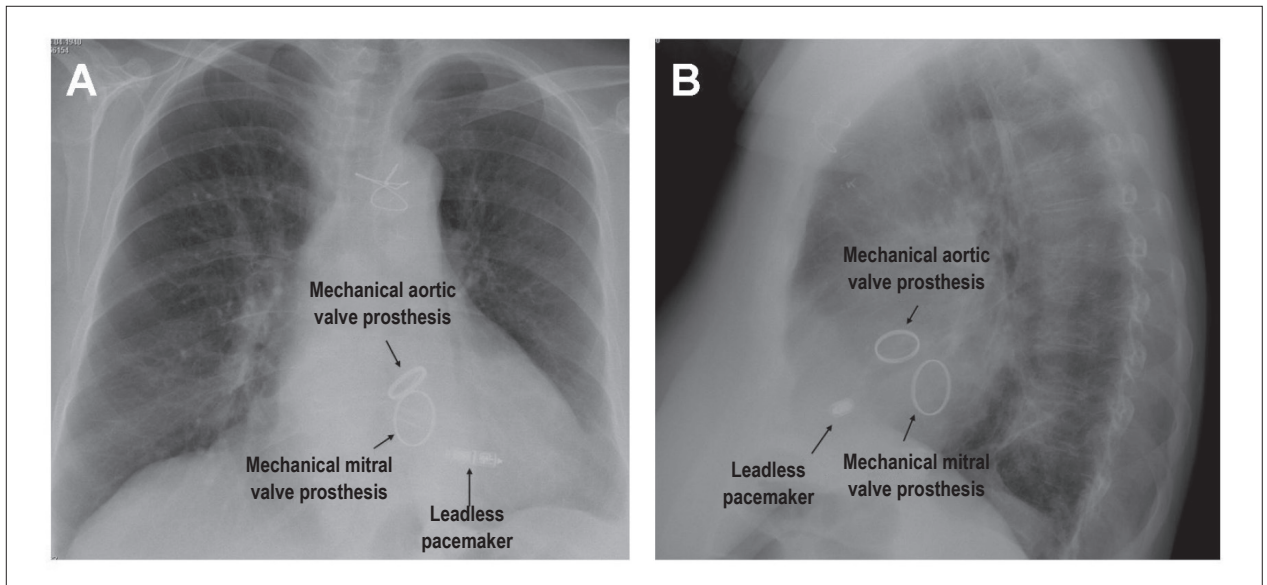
Chest X-Ray of the patient (panel A, posteroanterior view; panel B: lateral view) after leadless pacemaker implantation.
